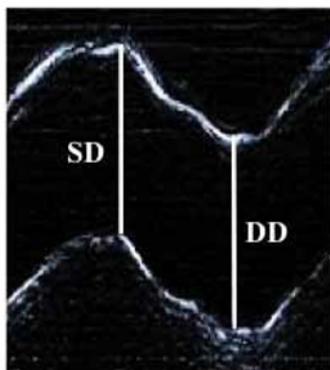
Measurement of systolic (DS) and diastolic (DD) ascending aortic diameter is presented on an M-mode echocardiographic image obtained at a level 3 cm above the aortic valve (Figure 1A).
